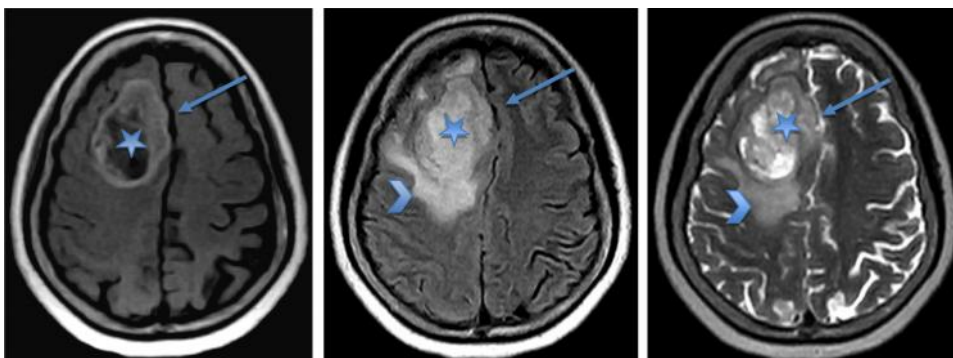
Post-contrast T1W, FLAIR and T2W images of a known GBM patient showing an oval-shaped mass (star) with cystic and solid components in the right parietal lobe. There is heterogeneous enhancement of the solid portion, mass effect- evidenced by shift of the midline (arrow) and peri-lesional edema (arrowhead).
